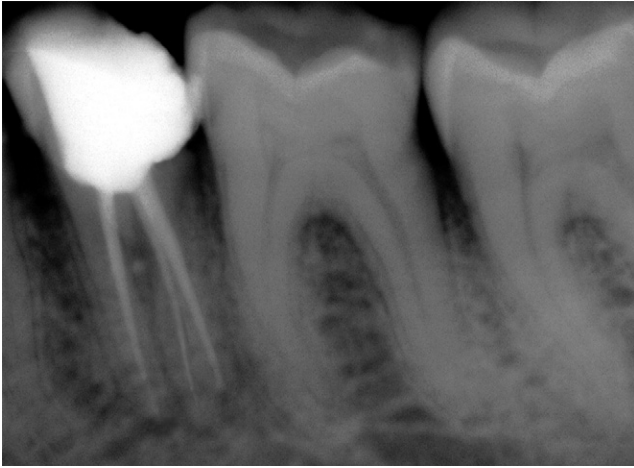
Pre operative radiograph revealing unusual root canal anatomy of tooth #20 with distolingual canal obturation short of apex.
